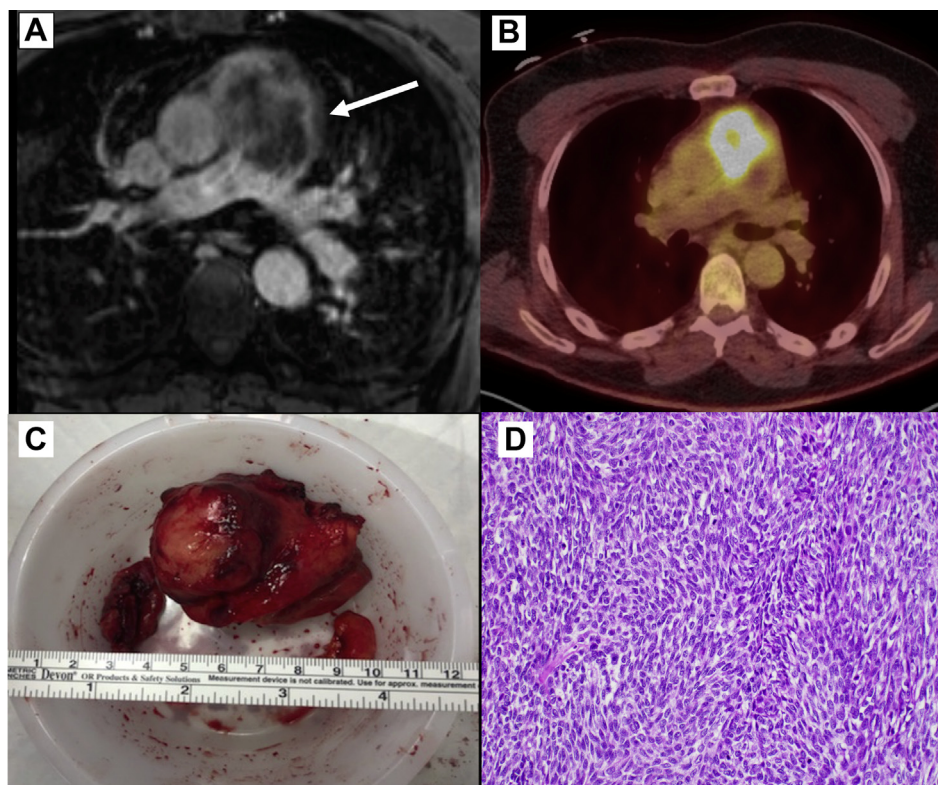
(A) On contrast-enhanced magnetic resonance imaging, the lesion (white arrow) shows intense heterogeneous enhancement. (B) The axial positron-emission tomography-computed tomography fused image shows increased fluorodeoxyglucose uptake of the main pulmonary artery mass. (C) Macroscopic photo of the tumour. (D) Surgical biopsy of the cardiac mass (200× magnification). The tumour is composed of highly cellular fascicles of spindle cells with prominent mitotic activity.
